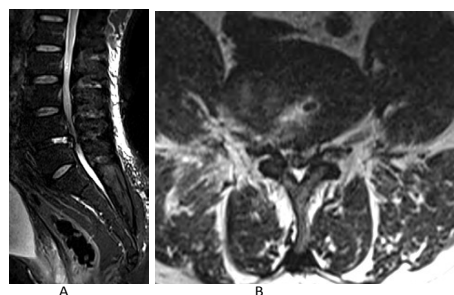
First surgery postoperative MRI done following initial procedure showing decompressed canal with residual disc.
